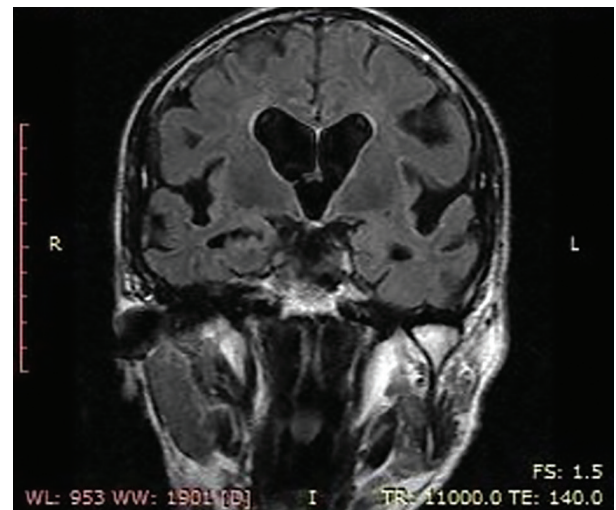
MRI of a 85-year-old female patient with VaD, showing white periventricular hyperintensities on the FLAIR sequence (Fazekas PV 3).
